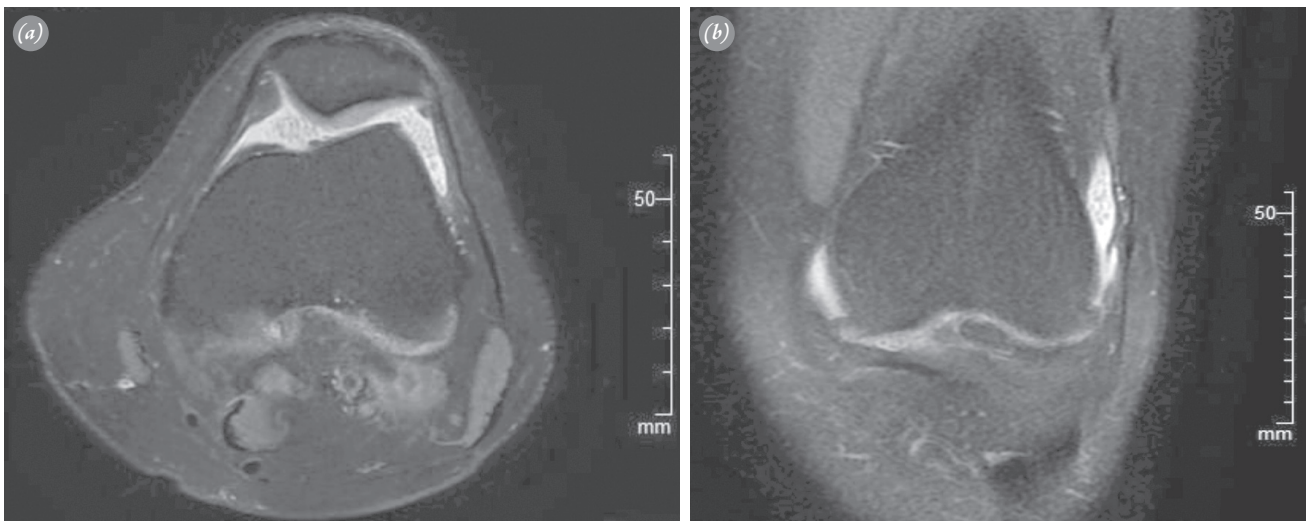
(a, b) MRI images show multiple free-floating intra-articular flake-shaped rice bodies.
